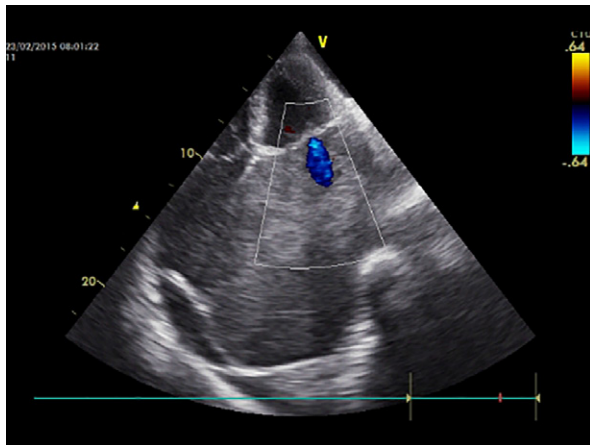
Transthoracic echocardiogram of the left atrium (apical 4-chamber view in color-flow Doppler mode) shows mild mitral insufficiency.
